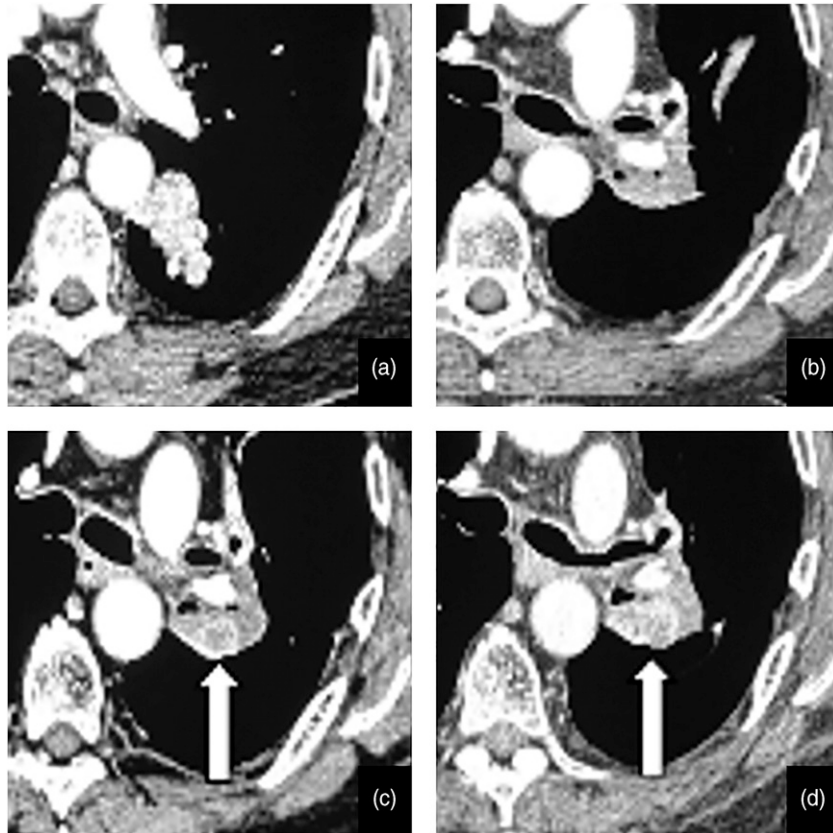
(a). Index scan demonstrating 3.6 cm lobulated enhancing mass in the superior segment of the left lower lobe. The mass was biopsy proven adenocarcinoma. (b). Follow-up scan post-chemo and radiotherapy after 3 years from index scan: Post-treatment fibrotic changes in the left hilum. No enhancing nodule within. (c). 6 months follow-up contrast-enhanced CT shows enhancing nodule measuring 1.8 cm within the post-treatment fibrotic changes, concerning for recurrence. This nodule was initially missed. (d). Interval increase in size of the enhancing nodule to 2.6 cm, in the 6 month-follow-up scan.
